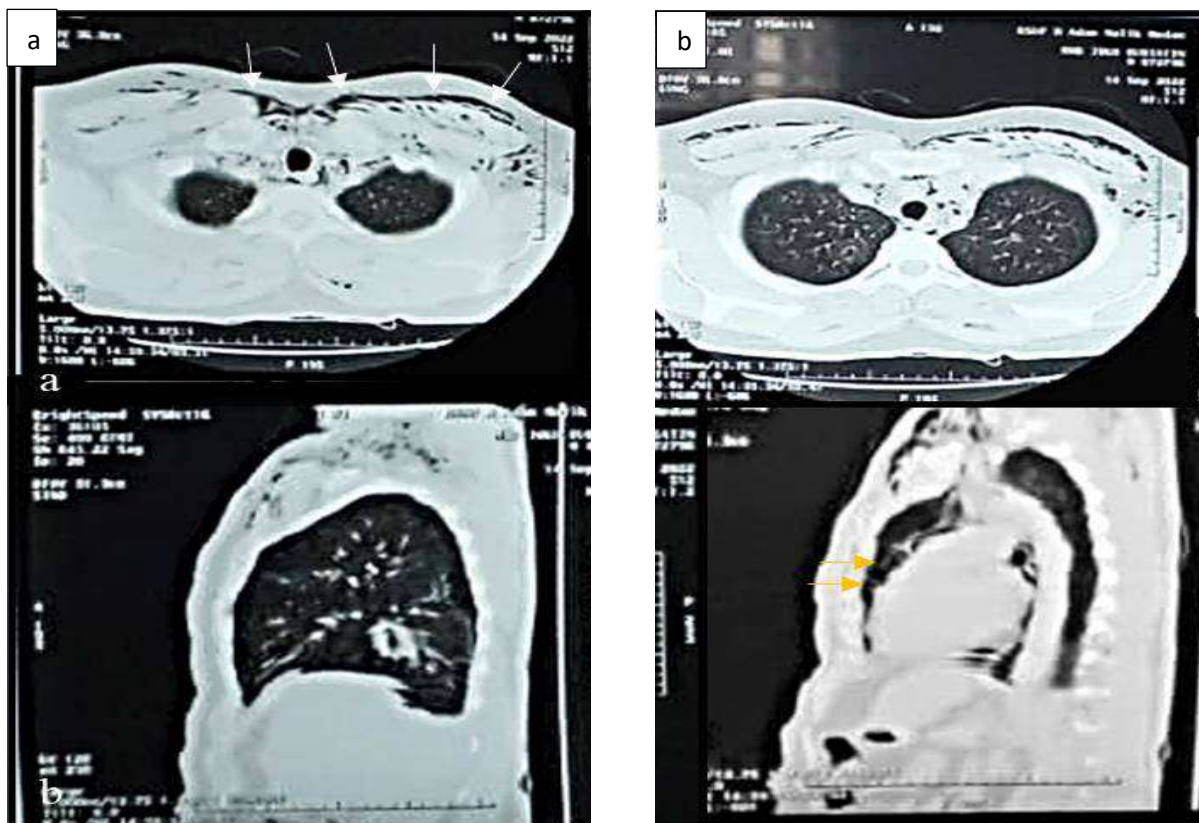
Thoracic computed tomography (CT) (a) axial view and (b) sagittal view. Subcutaneous emphysema extending to the neck and chest wall (white arrow) and free air in the anterior part of the mediastinum (yellow arrow) where pneumomediastinum was confirmed and pneumothorax was excluded.
